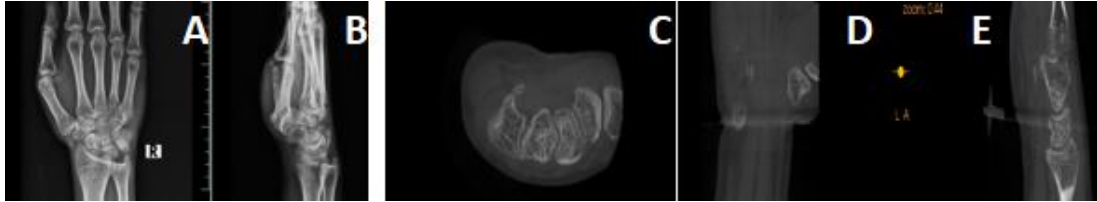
Hook of hamate fracture. The fracture is not visible on general radiographs (A,B) but is clearly evident on CBCT images (C-E).
